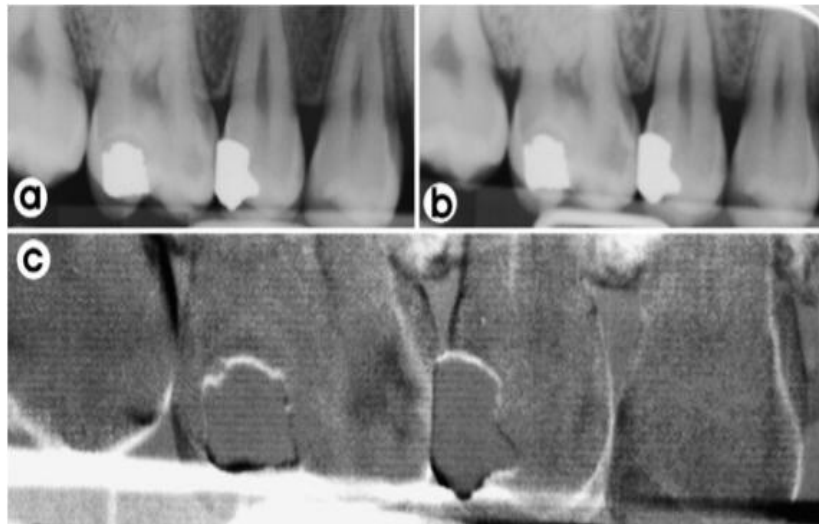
(a) Radiograph showing proximal lesion on mesial surface of first molar, (b) Follow up radiograph taken 12 month later, (c) The areas of different between the films are shown as black i.e in this case the proximal lesion has become more radiolucent
